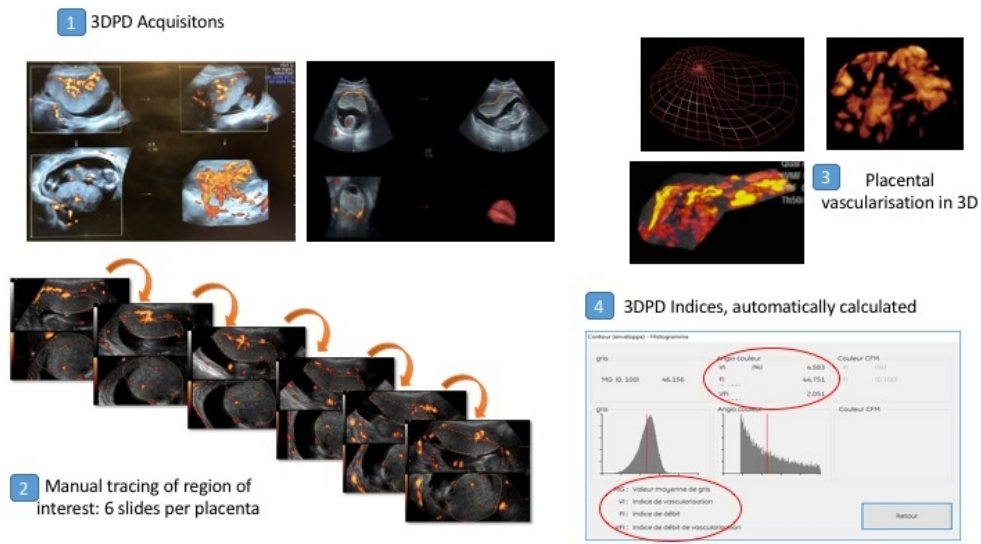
Three dimensional Power Doppler (3DPD) Analysis
